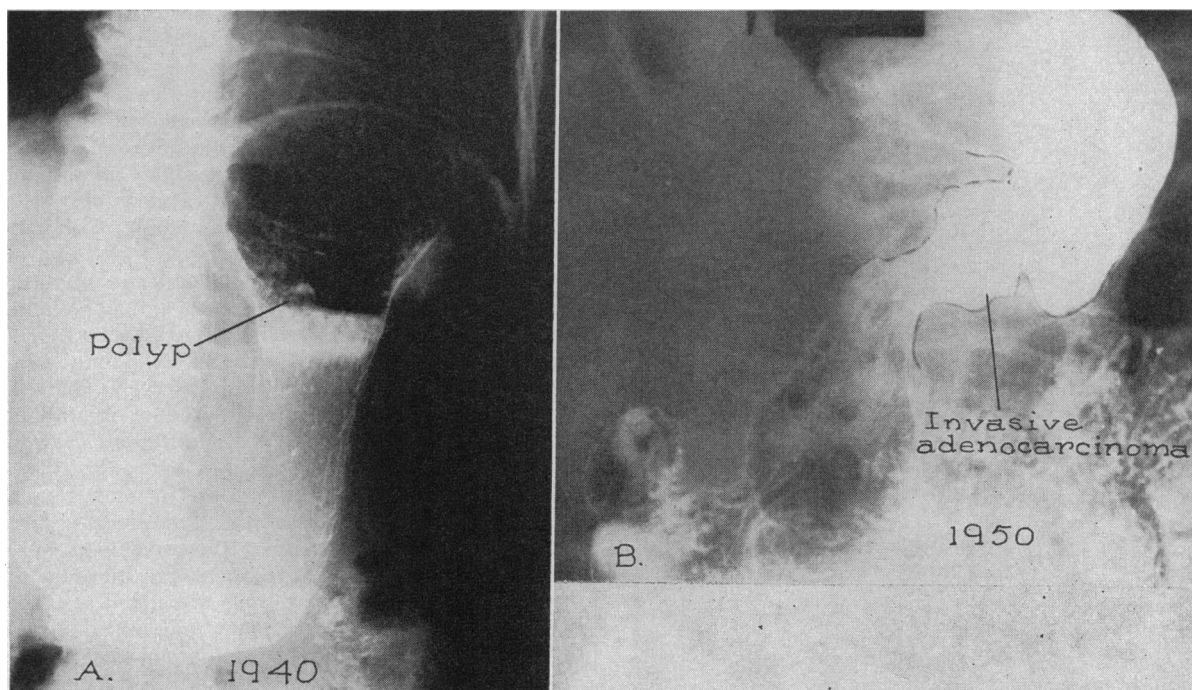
A*—Polyp on the anterior wall of the upper stomach. *B*—Repeat x-ray studies in the presence of clinical symptoms demonstrated a large infiltrating gastric carcinoma in the exact site of the gastric polyp noted ten years previously.
